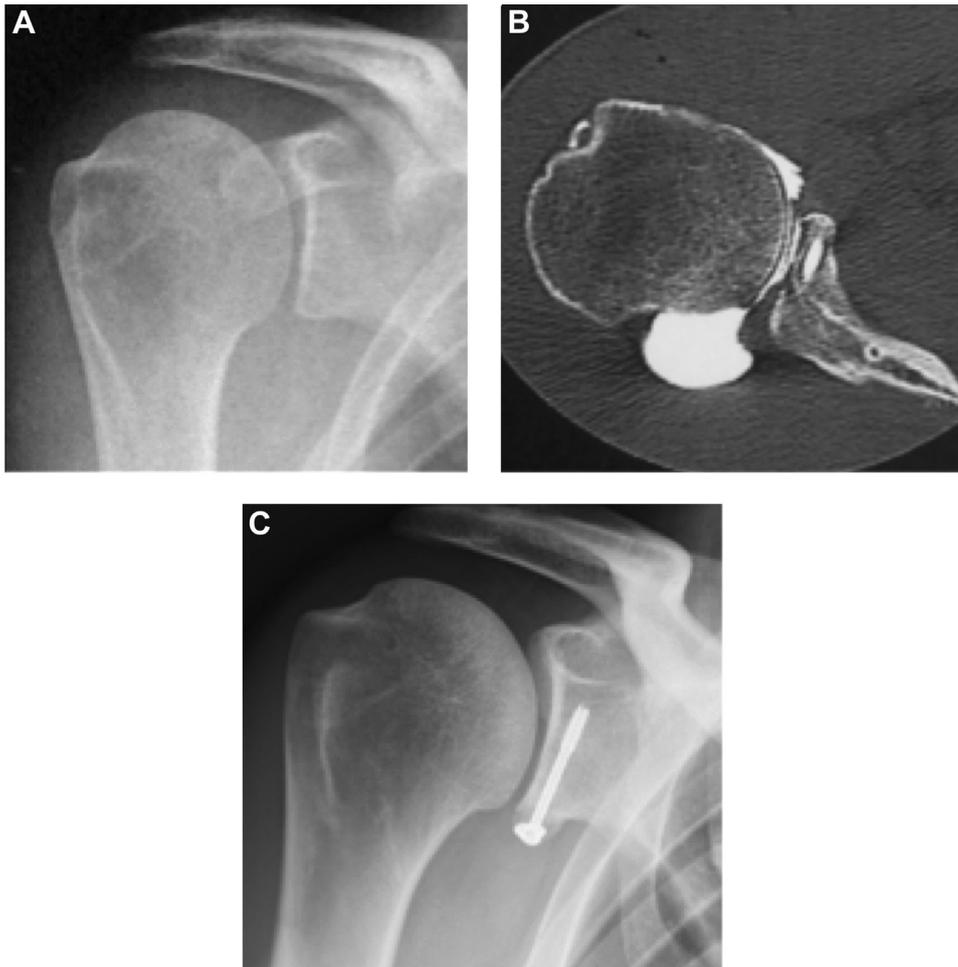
Arthroscopic Bankart revision by arthroscopic coracoid bone-block. (A) Before revision: no osteoarthritis. (B) Postoperative computed tomographic scan: no overhanging bone-block. (C) No osteoarthritis after 8 years of follow-up.
